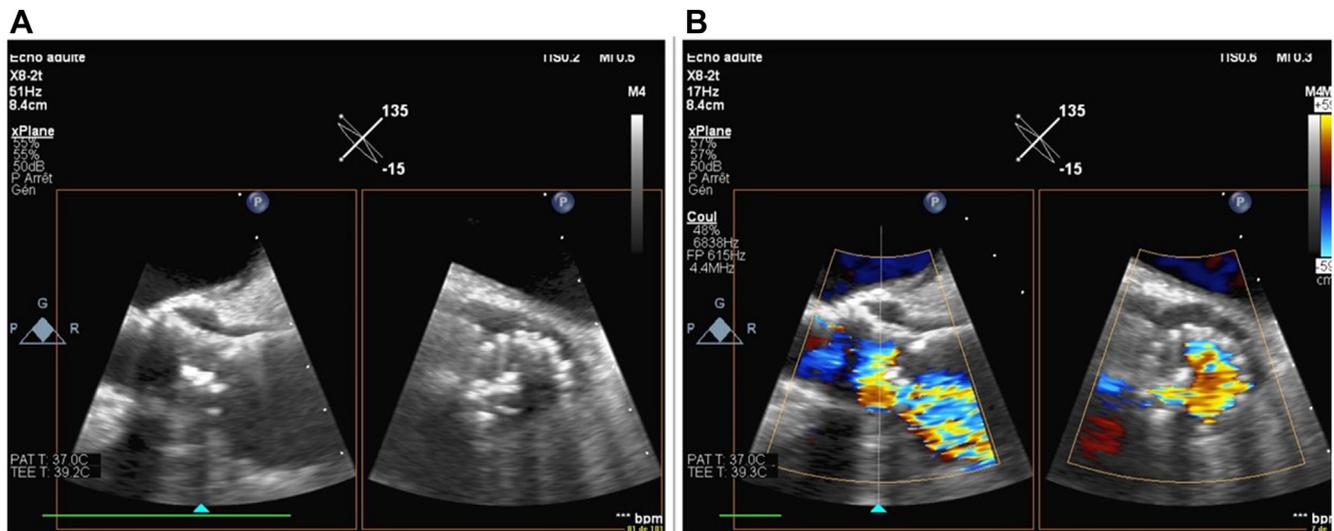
Example of structural valve deterioration secondary to infective endocarditis. (A) Transesophageal echocardiography: mid-esophageal biplane view focused on the aortic prosthesis in a patient who underwent transcatheter aortic valve replacement 2 years earlier. Note the prosthesis leaflet calcification that results in reduced prosthesis opening. (B) Same view with colour Doppler in systole showing colour Doppler aliasing and noncircular transprosthetic flow.
